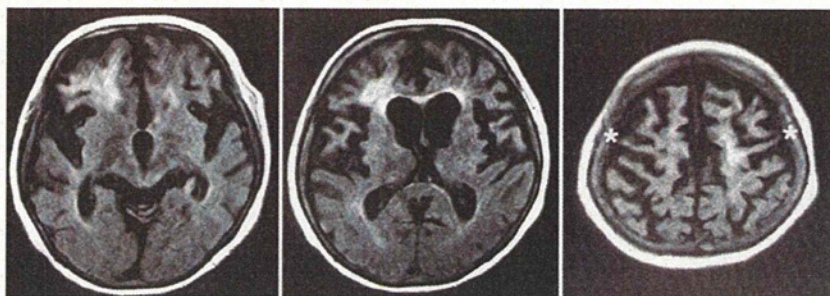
Fluid-attenuated inversion recovery (FLAIR) images obtained from case 1 about 11 weeks before death. Atrophy of the frontal lobe, particularly the precentral gyrus, is evident, with dilatation of the lateral and third ventricles and enlargement of the sylvian fissure. The basal ganglia also appear atrophic. Asterisks indicate the bilateral precentral gyri.
